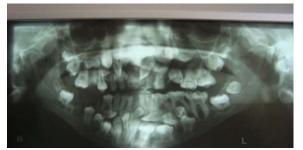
Orthopantomogram view of the jaws showing several unerupted teeth.
